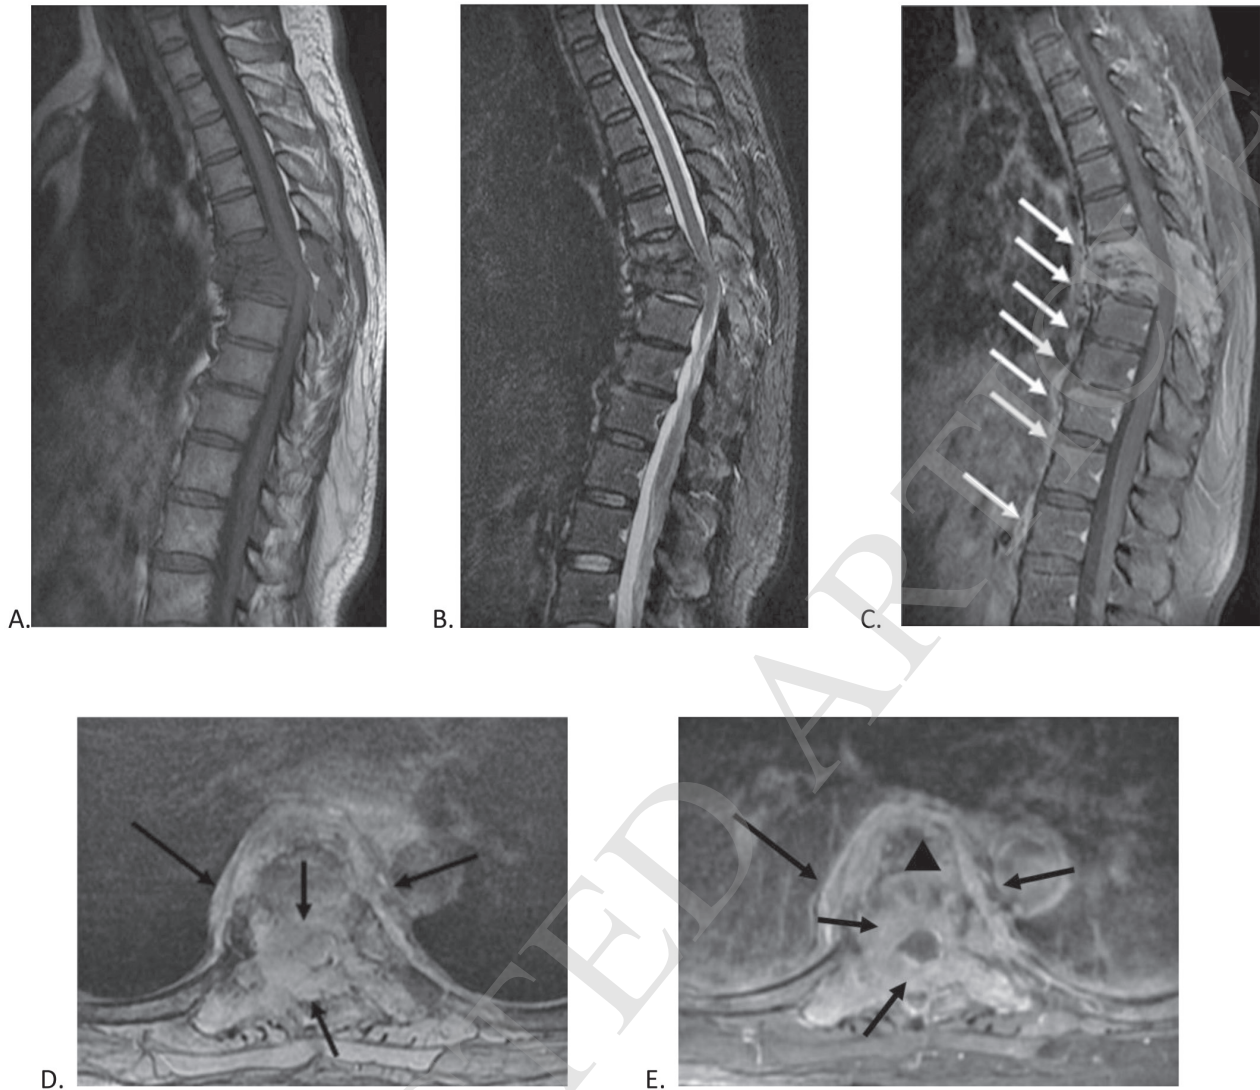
Tuberculous spondylodiscitis. A 47-year-old woman with back pain and weakness of both legs for 2 months. A. T1-weighted sagittal MRI shows collapsed T6 and T7 vertebrae with diffuse T1 hypointensity involving both vertebral bodies and posterior element. Kyphotic change or gibbus deformity at this level is seen. B. T2-weighted, fat-saturated sagittal MRI demonstrates abnormal T2 hyperintensity in the T6 and T7 vertebral bodies in both vertebral bodies and posterior elements. Severe narrowing of the spinal canal with cord compression is seen. Marked narrowing of the T6-7 disc space without definite T2 hyperintensity is noted. C. Postgadolinium, fat-saturated T1-weighted sagittal MRI reveals diffuse bone marrow enhancement corresponding to the abnormal vertebral marrow T1 signal. There is subligamentous spread of infection beneath the anterior longitudinal ligament down to the T12 level. (white arrows) Evidence of disc enhancement, enhancing ventral and dorsal epidural soft tissues and thin anterior paraspinal contrast enhancement is seen. D. T2-weighted, fat-saturated axial MRI and E. Postgadolinium, fat-saturated T1-weighted axial MRI confirms the vertebral marrow enhancement (black triangle) and enhancing paraspinal and epidural soft tissues (black arrows) encircle the thoracic cord resulting in cord compression. In this case, the epidural and paraspinal enhancement represents inflammatory phlegmon and/or venous engorgement without discrete abscess formation. The patient underwent T6-7 laminectomy to decompress the spinal cord and remove the epidural soft tissue. Tissue culture was positive for *M. tuberculosis*.
